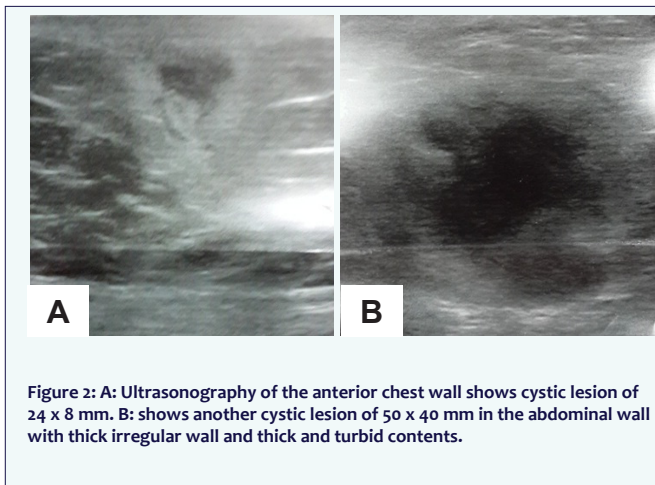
A: Ultrasonography of the anterior chest wall shows cystic lesion of 24 x 8 mm. B: shows another cystic lesion of 50 x 40 mm in the abdominal wall with thick irregular wall and thick and turbid contents.
